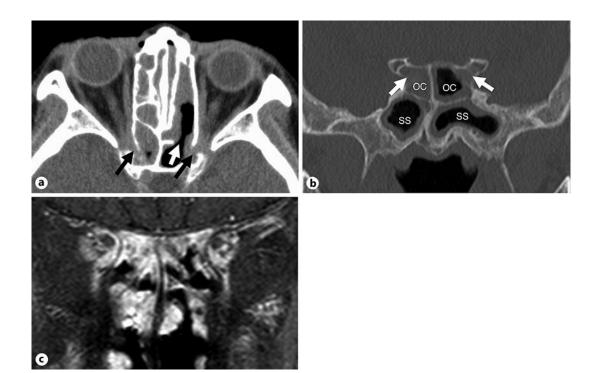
Imaging test. a, b Axial (a) and coronal section (b) images of computed tomography. c Coronal section image of T1-weighted image enhanced by gadolinium. The black arrows indicate a bone defect of the lateral wall of the Onodi cell (a). The white arrow indicates the opening between the posterior ethmoid and the Onodi cell on the left side (a). The coronal section of CT depicted the posterosuperior walls of the Onodi cell, which became faint and were accompanied by infiltrative changes (white arrows in b). Magnetic resonance imaging revealed severe inflammatory changes in the bilateral orbital apex (c). OC, Onodi cell; SS, sphenoid sinus.
